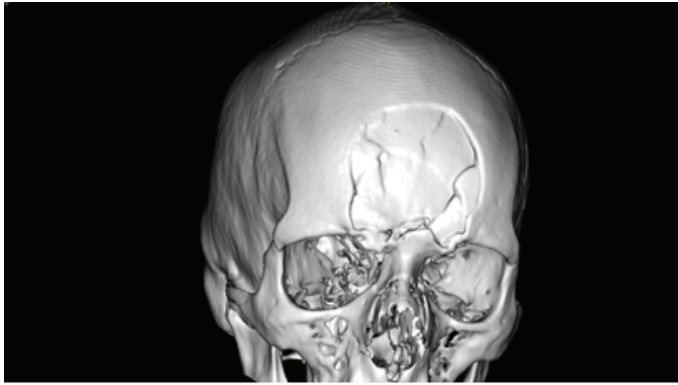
Brain CT scan with 3D reconstruction depicting area of damage and comminute and depressed fracture of the frontal bone
